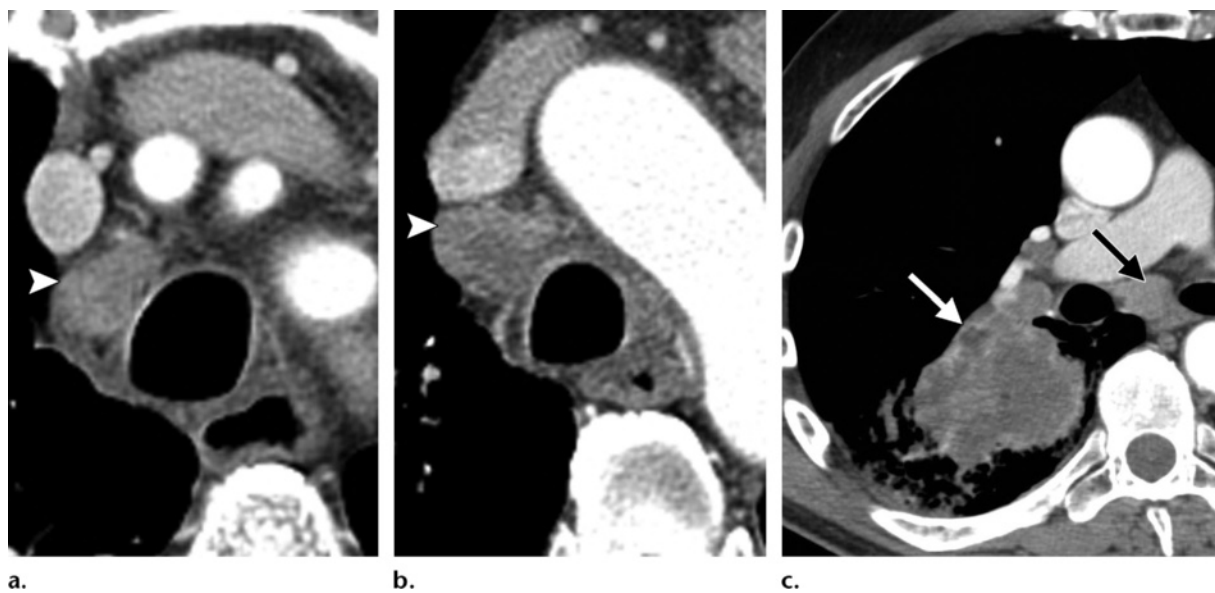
Stage N2 lymph nodes. (a) Chest CT scan shows an enlarged (1.6-cm) right upper paratracheal lymph node (level 2) (arrowhead). (b) Chest CT scan obtained in a different patient shows an enlarged (1.5-cm) right lower paratracheal lymph node (level 4) (arrowhead). Like the lymph node in a, it is clearly to the right of the new border proposed by the IASLC (ie, the left lateral border of the trachea). (c) Chest CT scan obtained in a third patient shows a right lower lobe mass (white arrow) with an enlarged (1.6-cm) subcarinal lymph node (level 7) (black arrow).
